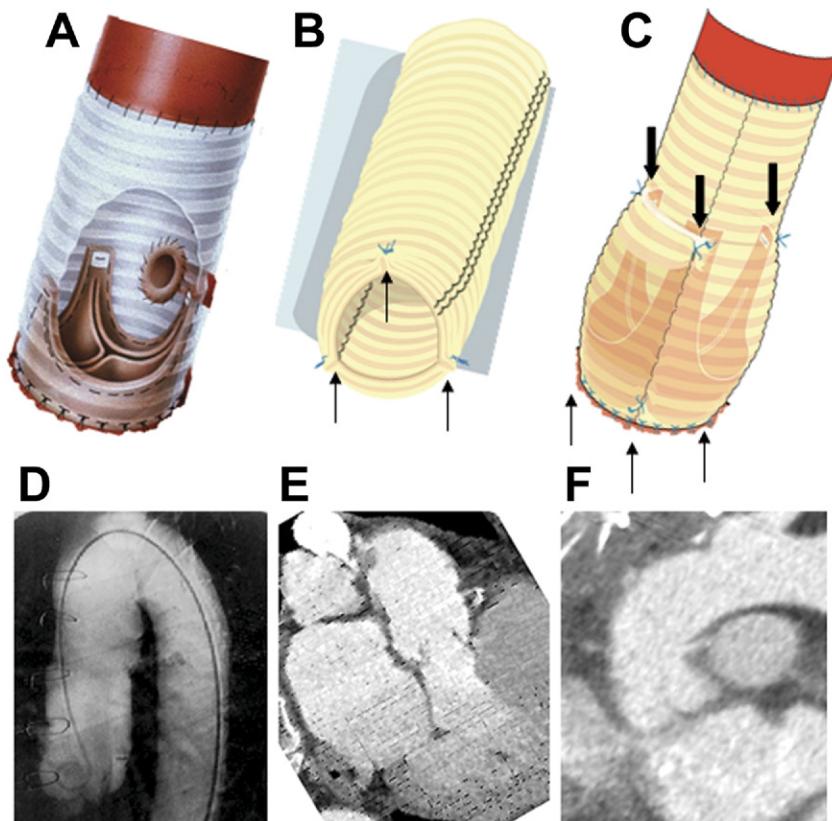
(A) Standard David technique. (B) Pseudosinus technique; arrows show three stitches (5-mm triangular bites) at the base of the prosthesis with 4-0 braided polyester sutures. (C) Neosinus technique; bold arrows show the additional three stitches (5-mm triangular bites) at the top of each commissure perpendicular to the lower edge of the prosthesis (light arrows). (D) Angiography (of the standard David technique). (E) Computed tomographic scan of the heart, pseudosinus technique. (F) Computed tomographic scan of the heart, neosinus technique.
